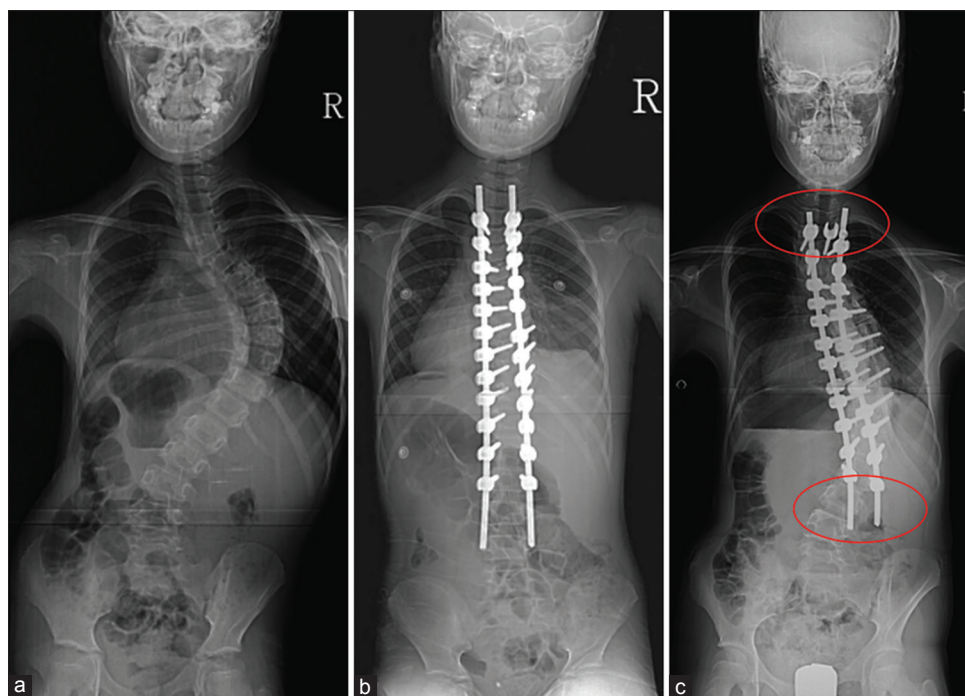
(a) X-ray of whole spine anteroposterior view showing Risser stage was 0 and the Cobb's angle 71°. (b) After operation, Cobb's angle was corrected from 71° to 12°. Considering the vertebral growth, the longer rod than exact vertebral length was used. (c) At 3 years followup, patient's Cobb's angle had progressively worsened from 12° to 46°. However, shortening of the spare length of the rod (which was inserted at initial surgery for guided spine growth) was observed (red circle)
